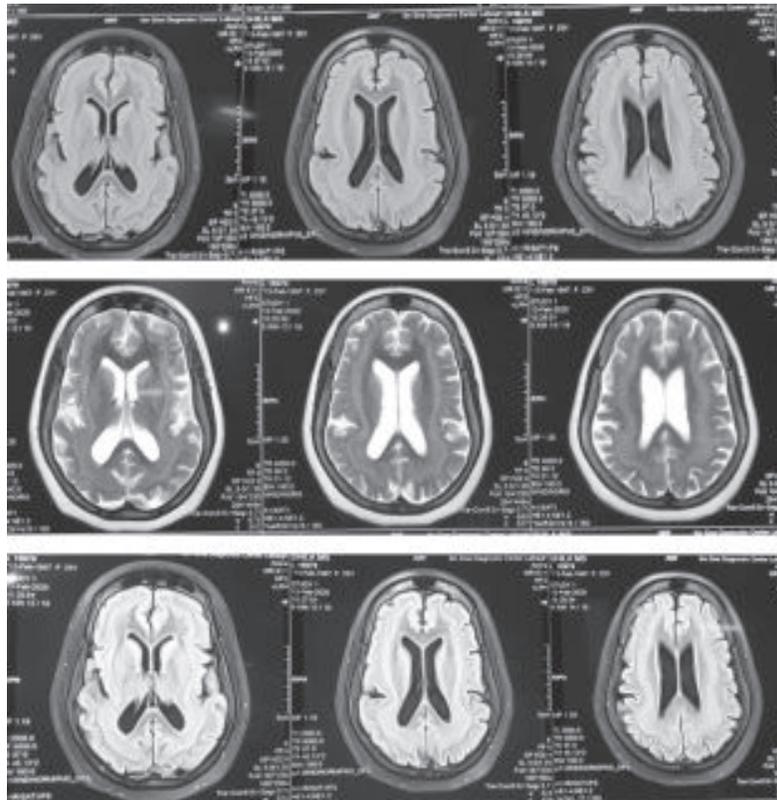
MRI of Brain T1 T2 FLAIR sequence revealed a band of grey matter located deep to, and roughly paralleling, the cortex, with pachygyric overlying cortex. The band of abnormal grey matter is complete. There is posterior predilection.
